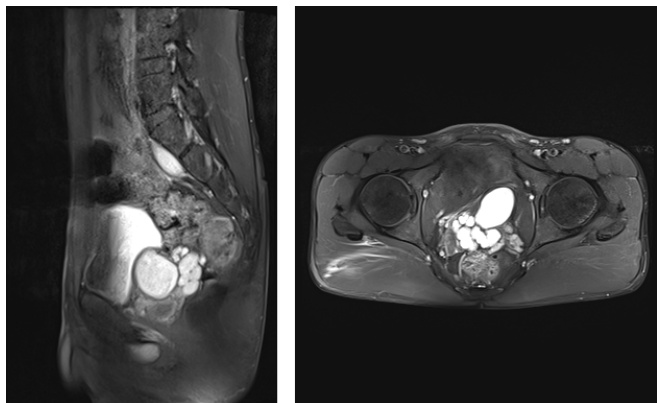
2019 MR images (sagittal and axial sections)
